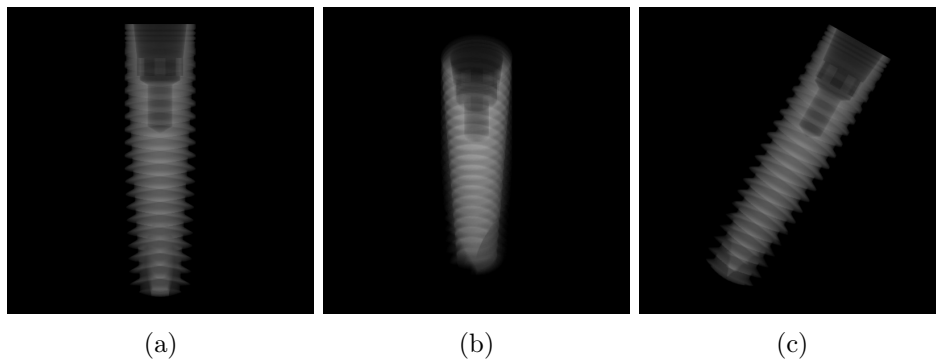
Examples of the artificially generated X-ray images employed for training the proposed FCN-1 model.
